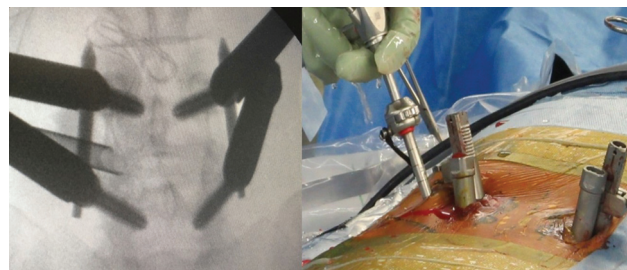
Intraoperative radiograph showing the surgical field. Four percutaneous pedicle screws are inserted, and the cannula is docked on the bony structure of the superior articular process.
